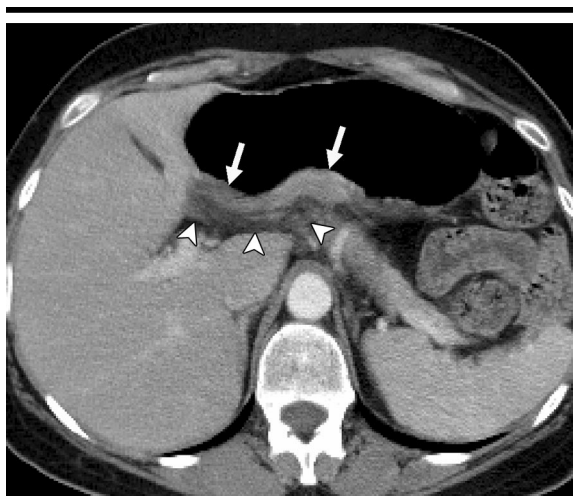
Transverse CT scan of a 47-year-old woman shows an antral tumor (arrows) with blurring of more than one-third of the tumor extent (arrowheads). The lesion was correctly staged as T3.
